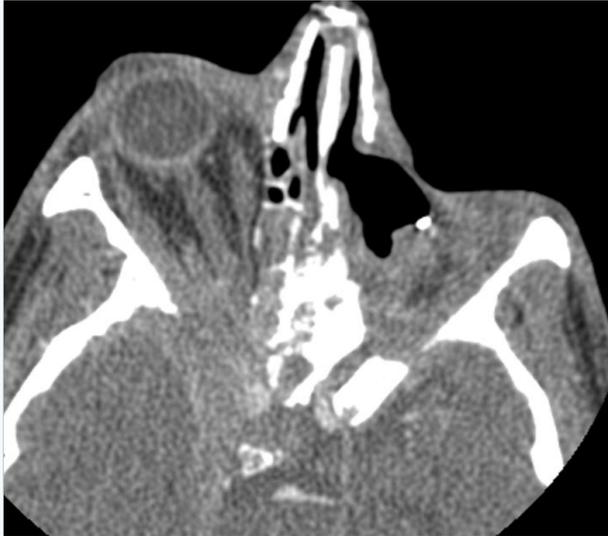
Computed tomography demonstrating proptosis and an orbital apex syndrome with extensive tumor invasion into the right orbit.
